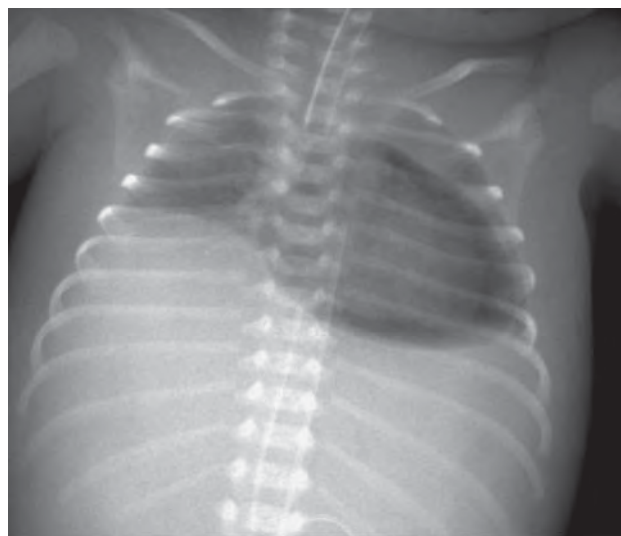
Frontal radiograph of the chest showing a large pneumopericardium in a patient after drainage of a large effusion.
